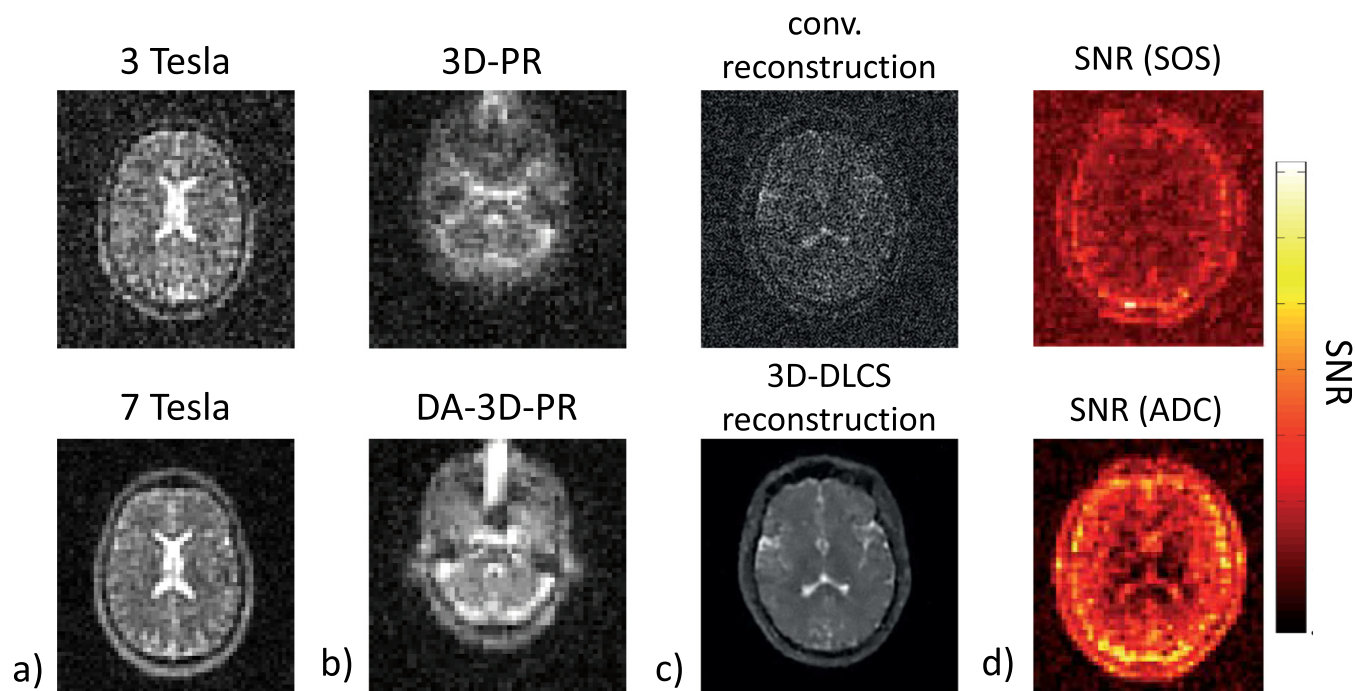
There are several possibilities to improve X-nuclei image quality. This is demonstrated for the example of ^{23}Na MRI. (a) Increasing the field strength leads to an approximately linear increase in SNR [283]. (b) Optimized acquisition techniques such as density-adapted sampling further increase SNR and reduce image artifacts [284]. (c) Iterative image reconstruction techniques such as 3D dictionary learning compressed sensing enable precise reconstruction with markedly reduced noise and artifact levels [285]. (d) Phased-array RF receive coils can further improve SNR. The adaptive combination (ADC) algorithm leads to a distinct increase in SNR compared to a sum-of-squares (SOS) reconstruction [286]. Parts of the figure were taken from [287,284], and [286] with permission of John Wiley and Sons. Part (c): Courtesy of Nicolas G.R. Behl, Medical Physics in Radiology, German Cancer Research Center (DKFZ), Heidelberg, Germany.
